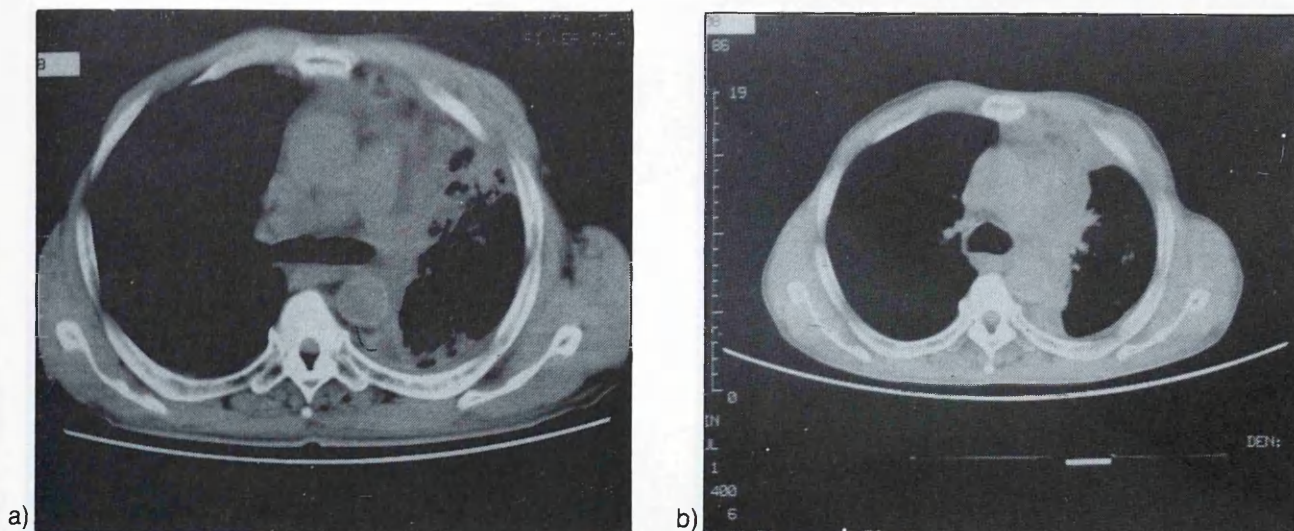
CT scan of the same patient a) pre-therapy b) post-therapy showed partial response to radiation therapy.
